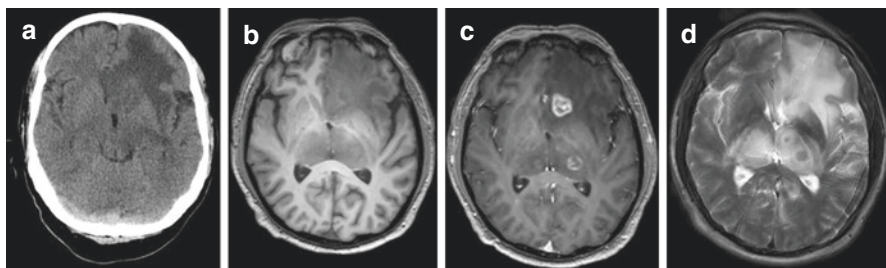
(a) CT without contrast, (b) MRI T1 without contrast, (c) MRI T1 with contrast, (d) MRI T2 without contrast of a 54-year-old HIV+ male found confused after a syncopal event following discharge from jail. Left frontal lobe mass with 4 mm midline shift and vasogenic edema identified on noncontrasted head CT (a), concerning for GBM vs. lymphoma vs. metastases. This prompted an MRI without contrast (b, d) radiologically concerning for CNS lymphoma, and a contrasted MRI (c) ordered the next day after admission and demonstrating ring-enhancing lesions, which can also be found with toxoplasmosis (Courtesy of Perrin Considine)
